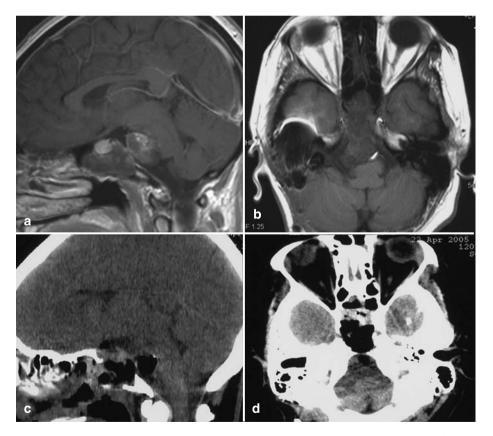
a, b) Sagittal and coronal pre-operative MRI images showing a case of clival chordoma. c, d) Sagittal and coronal post-operative CT images of the same patient showing the subtotal removal of the lesion
